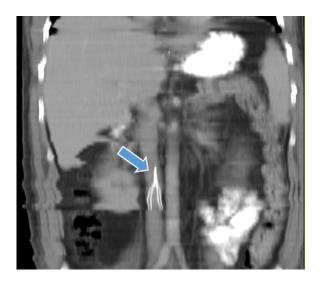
Reformatted average-intensity-projection contrast-enhanced CT image of the abdomen in the coronal plane demonstrating successful placement of a Gunther-Tulip IVC filter in the infrarenal vena cava in 2003.
